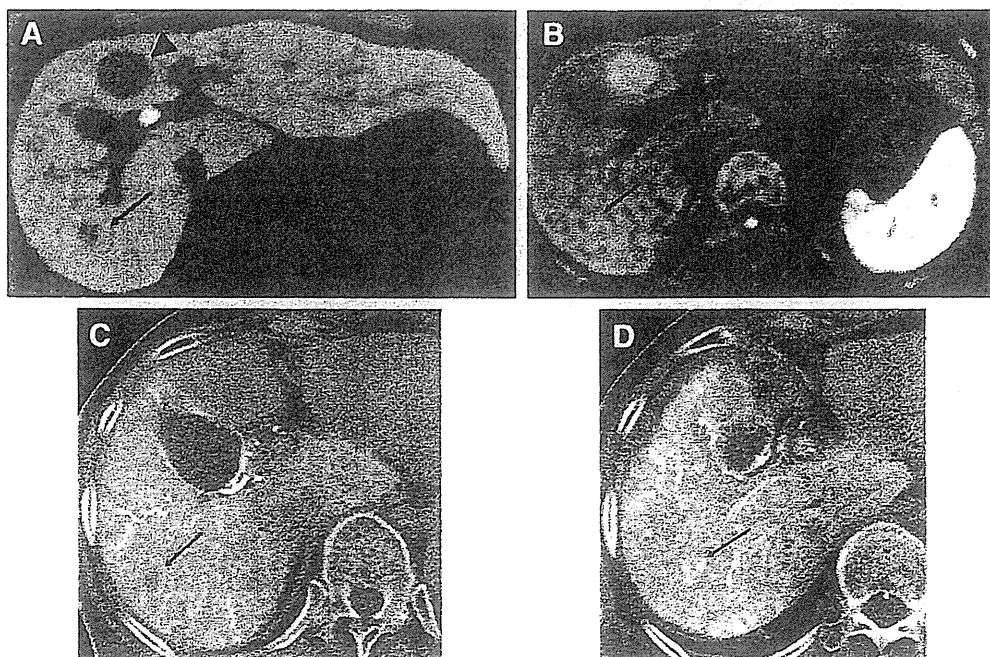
(A–D) A lesion in an 82-year-old woman was found to be vascularized 827 days from the initial diagnosis. (A) Hepatobiliary phase on Gd-EOB-DTPA-enhanced MRI shows a hypointense lesion on S7 (arrow). Another hepatocellular lesion which is partially hypervascular is shown on S4 (arrowhead). (B) DWI shows a hyperintense lesion on S7 (arrow). (C) Initial CTHA from the replaced right hepatic artery shows a low-density area on S7 (arrow). Another hepatocellular lesion is fed by the middle hepatic artery. (D) CTHA from the replaced right hepatic artery after 827 days from the initial vascularity evaluation shows high density on S7 (arrow).
